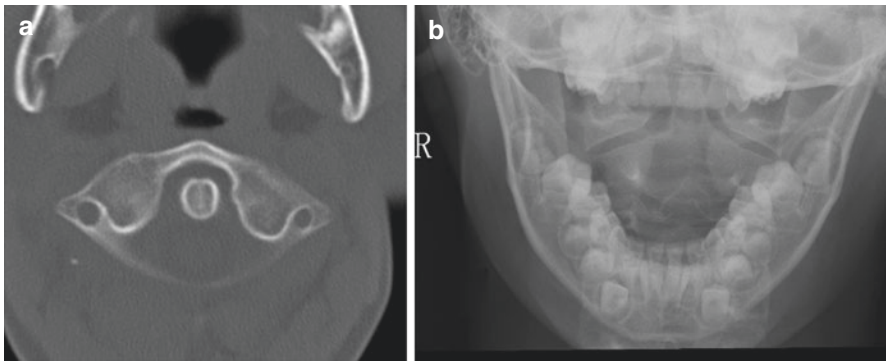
End of treatment ((a) CT scan; transverse section; (b) open mouth radiograph)
